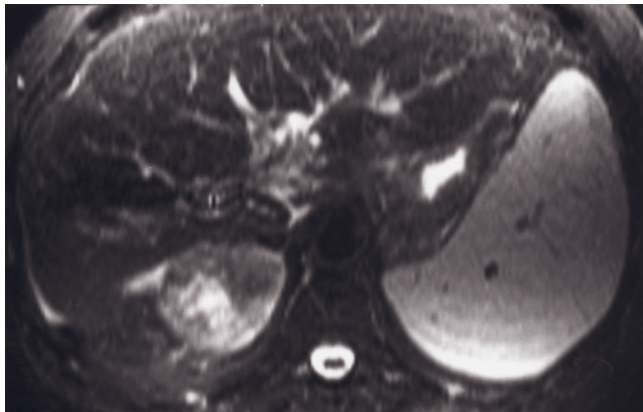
Adrenal metastasis with interval growth. Coronal T2-weighted echo-train spin-echo (a), T1-weighted GE (b), T1-weighted out-of-phase GE (c), T2-weighted echo-train spin-echo (d), immediate postgadolinium GE (e), and 90-s postgadolinium fat-suppressed GE (f) images. Coronal T2-weighted
